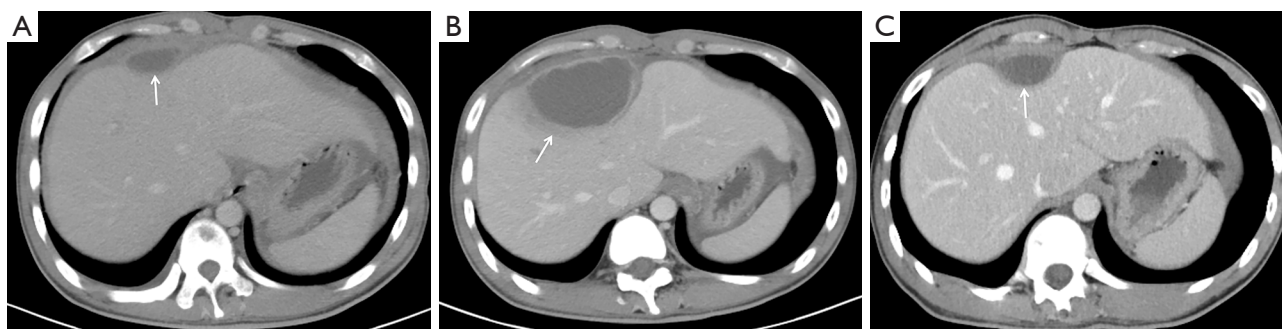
A 19-year-old male patient diagnosed with pulmonary, peritoneal, and hepatic tuberculosis, confirmed by a positive sputum culture for *Mycobacterium tuberculosis*. (A) An abdominal contrast-enhanced computed tomography scan in the portal venous phase, conducted on January 19, 2021, revealed substantial thickening of the perihepatic peritoneum and hepatic capsule, along with visible fusiform ring-enhancing lesions (as indicated by the white arrow), indicative of a capsular pattern. (B) A follow-up computed tomography scan, conducted on May 11, 2021, revealed further thickening and enhancement of the perihepatic peritoneum and hepatic capsule. The fusiform ring-enhancing lesions had enlarged significantly, with indistinct boundaries between the hepatic parenchyma and the lesions (as indicated by the white arrow), which was consistent with a paradoxical reaction. (C) A subsequent computed tomography scan, conducted on February 18, 2022, demonstrated a reduction in the size of the fusiform ring-enhancing lesions in the perihepatic peritoneum and hepatic capsule (as indicated by the white arrow).
